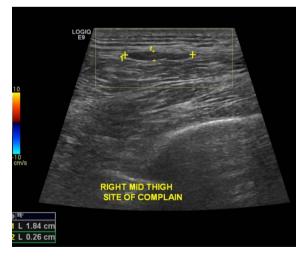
Ultrasound of the right thigh: well defined hypoechoic subcutaneous small collection in the mid-thigh.
